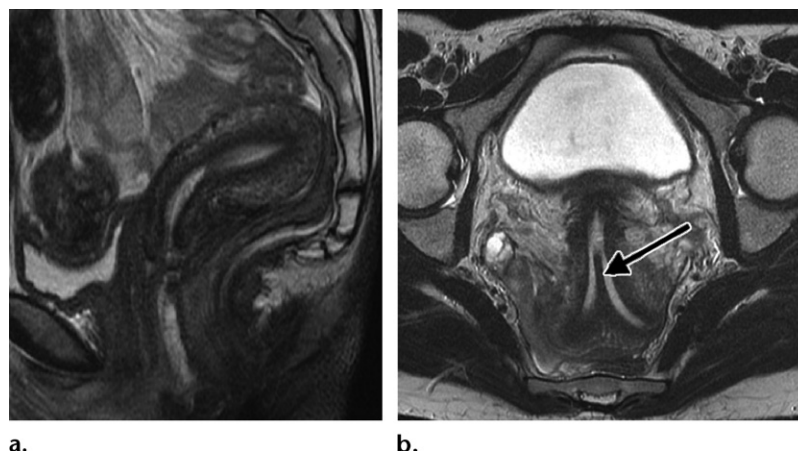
Müllerian duct anomalies identified at transvaginal US in a 32-year-old woman. Sagittal (a) and axial (b) FSE T2-weighted MR images show a septate uterus (arrow on b).
